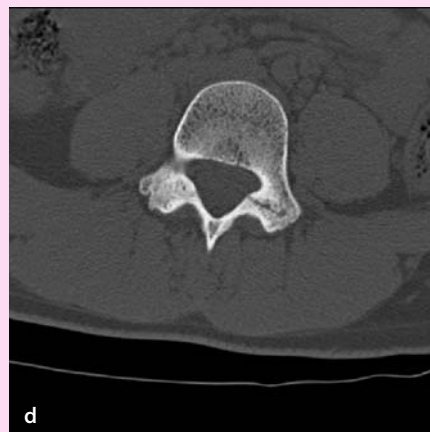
MRI characteristics of spondylolisthesis
